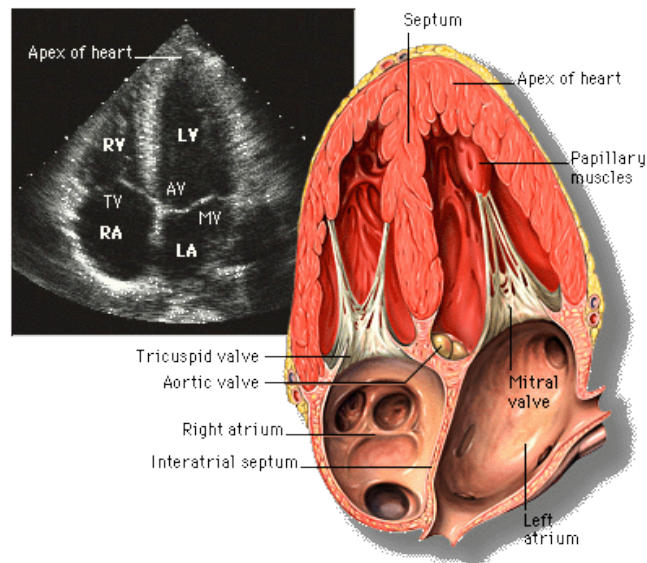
Normal apical 4-chamber view.(Feigenbaum2010)
